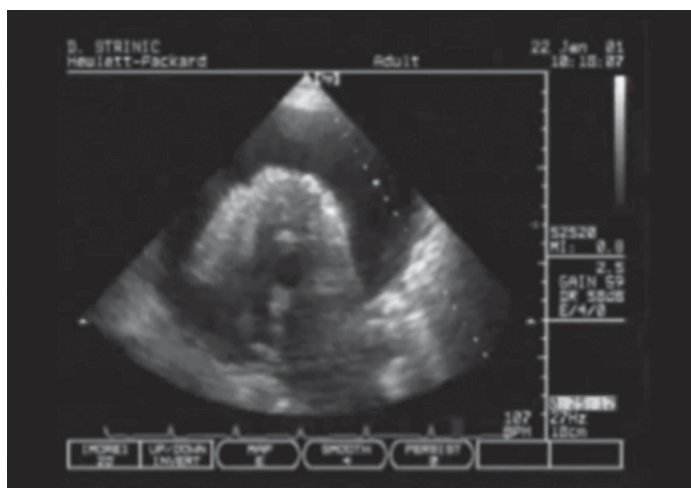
Reproduced from Lancellotti, P., Zamorano, J., Habib, G. and Badano, L. (2016). *The EACVI Textbook of Echocardiography*. 2nd ed. Oxford University Press. © European Society of Cardiology 2017. Reproduced with permission of the Licensor through PLSclear.
